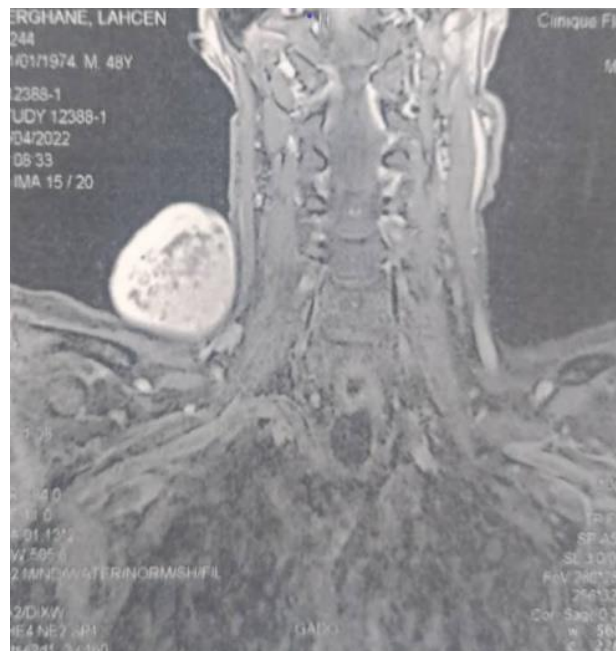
MRI images show a mass in hypersignal T2 and hyposignal in T1
